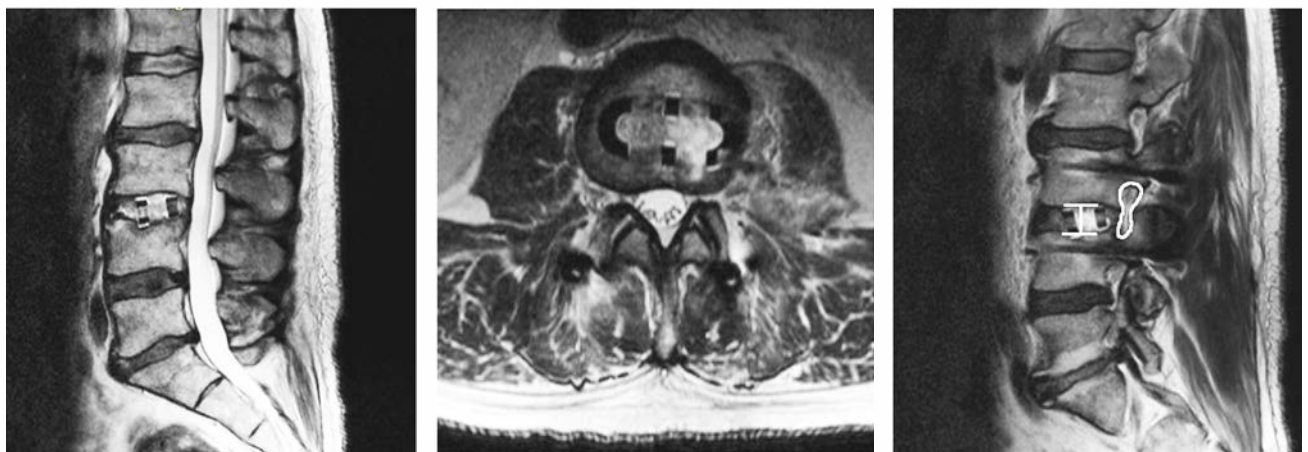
Postoperative lumbar MRI: (A) – sagittal T2-weighted image; (B) – axial T2-weighted image at L_{III} - L_{IV} level; (C) – intervertebral disc height (15.2 mm) and foraminal area on the sagittal image (145 mm²)
